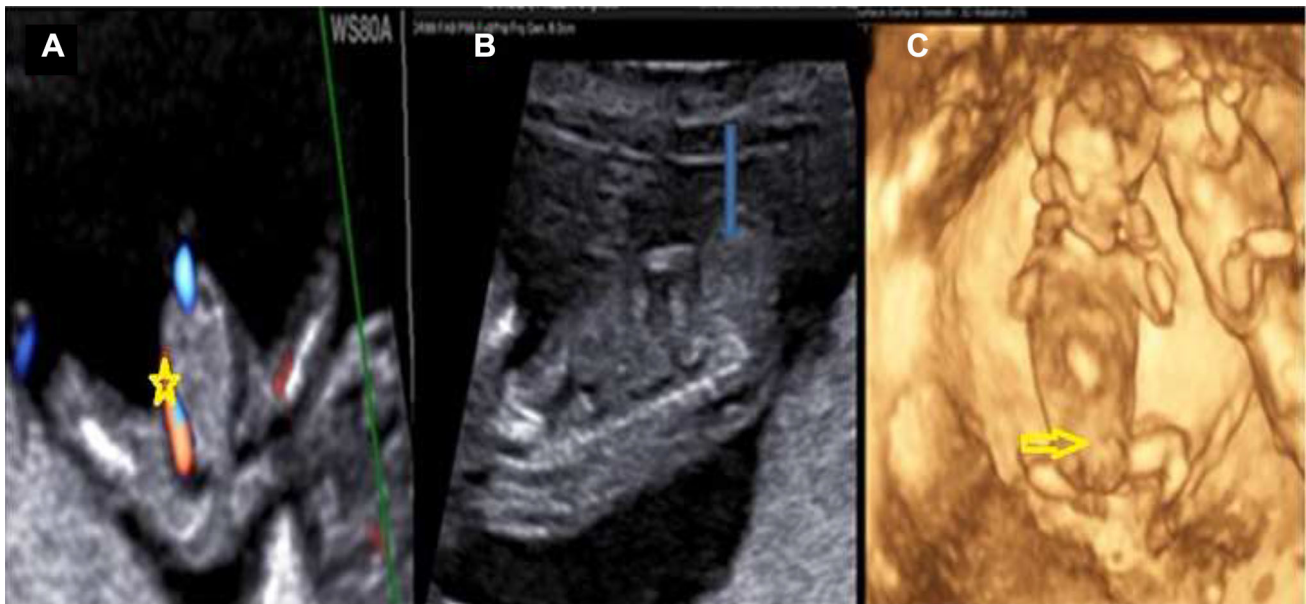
Ultrasound appearance of cloacal exstrophy. a Axial section suggestive of absent bladder, single umbilical artery (asterisk) outlining around heterogenous mass and wide apart thighs. b Sagittal
